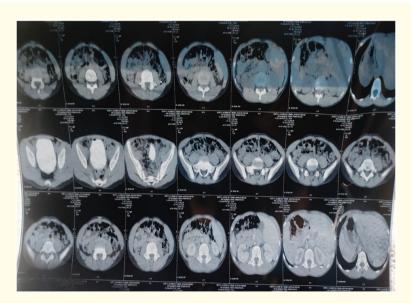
CT scan image suggestive of a linear, soft tissue density seen in the expected location of urachus with its proximal and distal ends thickened with a thin mid part.
